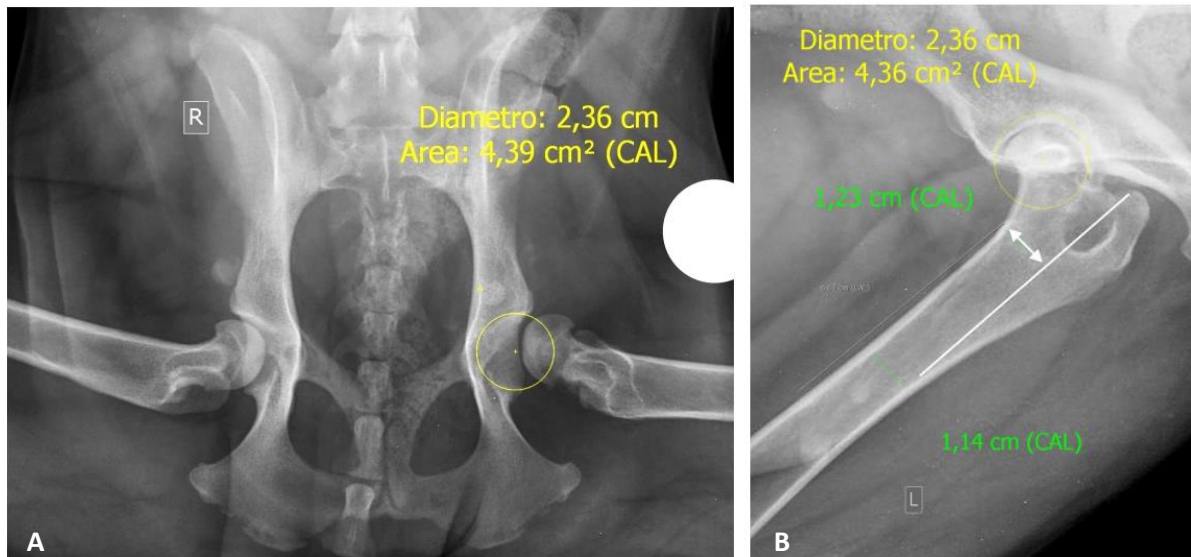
Measurement of the femoral head coverage on the hip-extended ventrodorsal radiographs of the pelvis (right). A circle, matching its curvature, was projected over the femoral head and the area covered by the acetabulum was measured (left). Femoral head coverage = area of coverage / area of circle x 100%.
